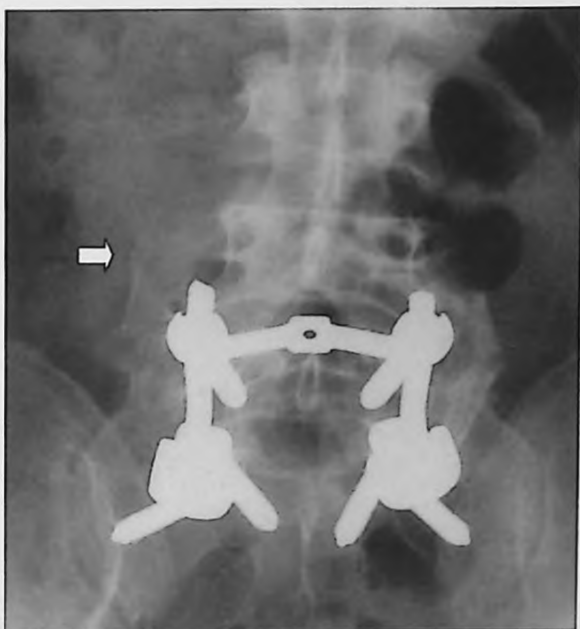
Anterior-posterior radiograph taken at the one-year follow-up showing a non-intended posterolateral fusion (arrows) adjacent to an intended posterolateral fusion with pedicle screw instrumentation.
